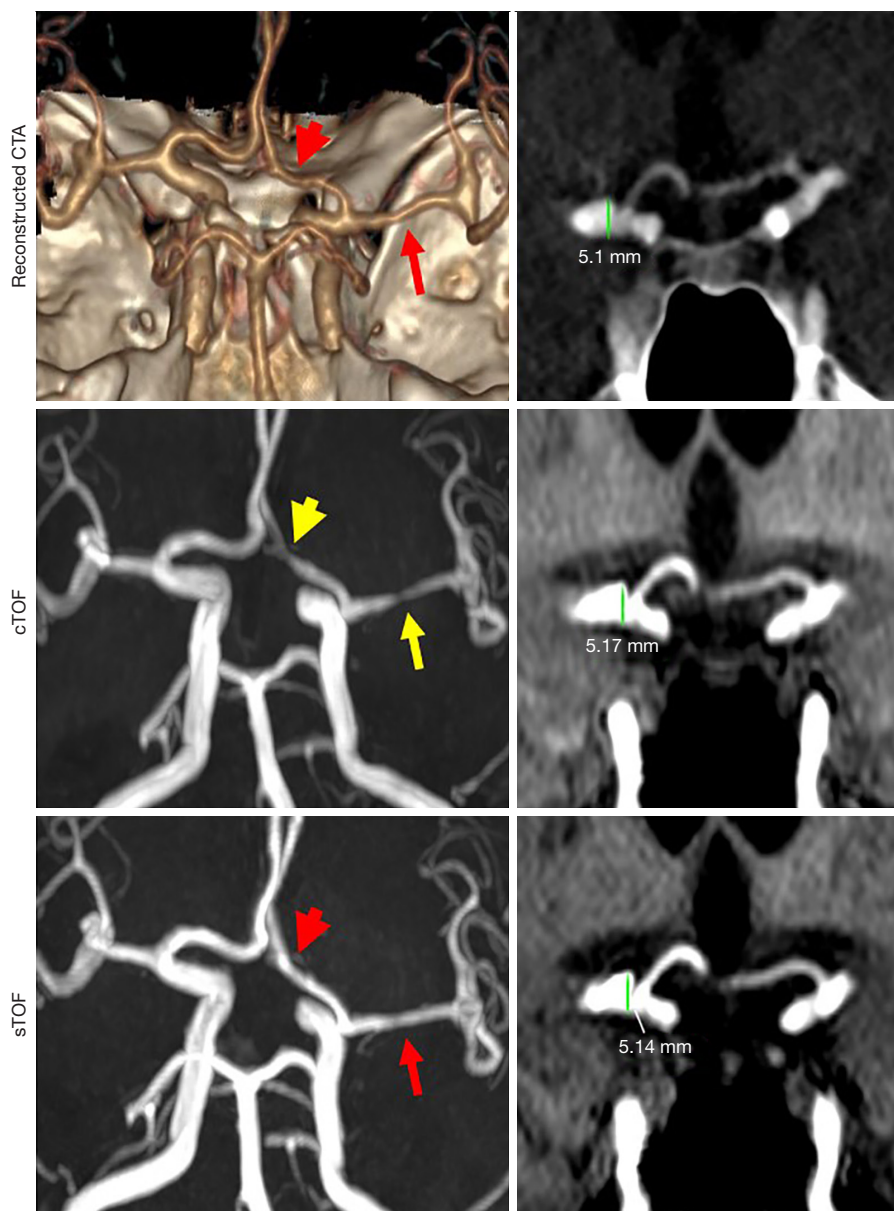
The above row shows reconstructed CTA, the middle and bottom rows show respectively the images of cTOF and sTOF. The left column shows the reliability of stenosis diagnosis at the A1 segment of ACA (short arrow) and the M1 segment of left MCA (long arrow). The right column depicts shape and size evaluation of aneurysm at the right proximal of MCA. CTA, computed tomography angiography; cTOF, Cartesian-based time-of-flight magnetic resonance angiography; sTOF, spiral-based time-of-flight magnetic resonance angiography; ACA, anterior cerebral artery; MCA, middle cerebral artery.
